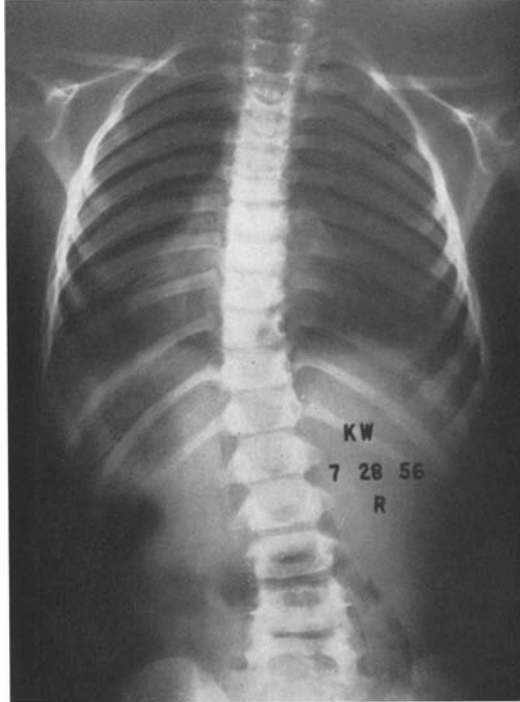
K. W. 1 year after the accident, a standing x-ray without the brace showed persistence of the structural curve. There appeared to be wedging of T 9 and 10. The brace was continued full time
